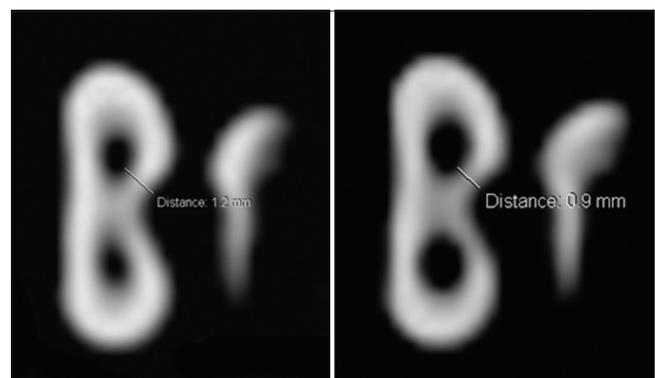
The cone beam computerized tomography scans of the pre and postpreparation images of the mesio-buccal canals of mandibular first molars
